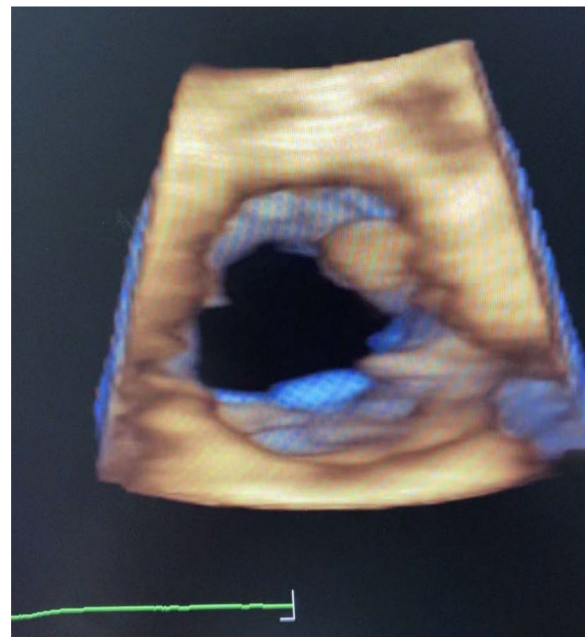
The aortic valve vegetation on three-dimensional (3D) echocardiography
